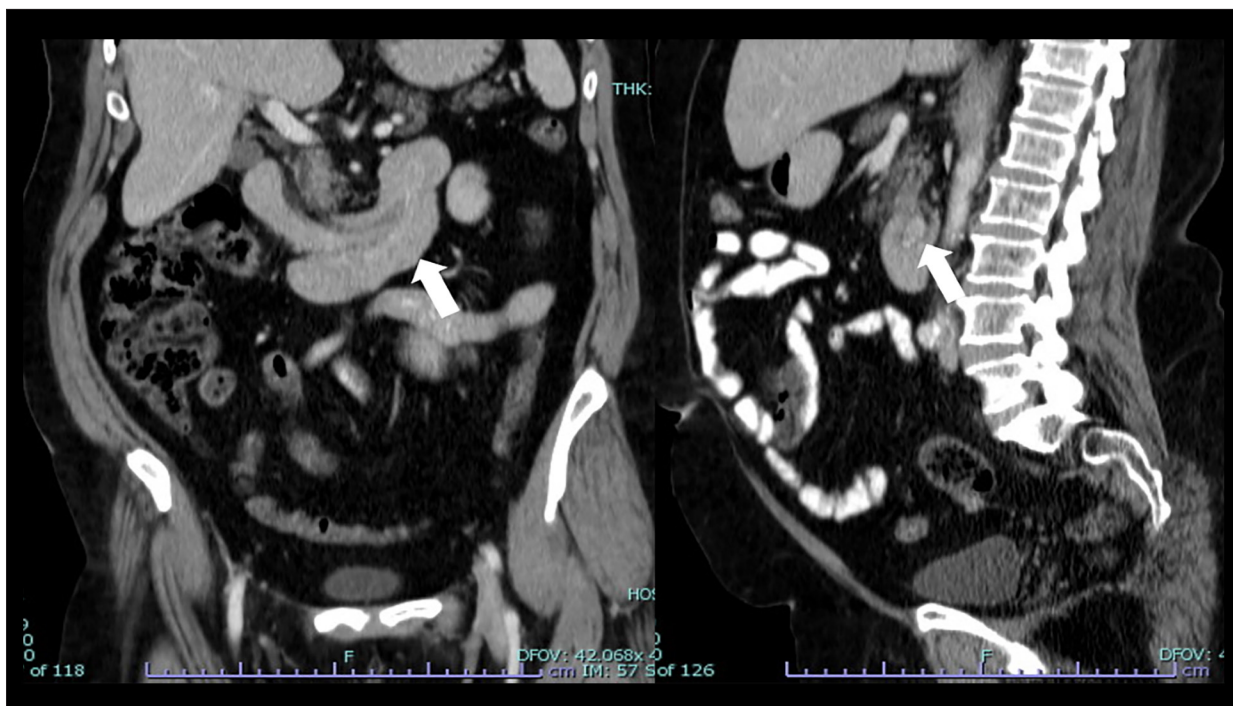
Coronal CT scan reconstruction with oral and intravenous contrast for a 64-year-old woman, demonstrating a segment of duodenal intussusception (arrow). Sagittal CT scan reconstruction for the same patient, demonstrating an enhancing polypoidal lesion (arrow) as a lead point for the lesion. The patient underwent surgical resection, which showed a tubular adenoma with low grade dysplasia.
